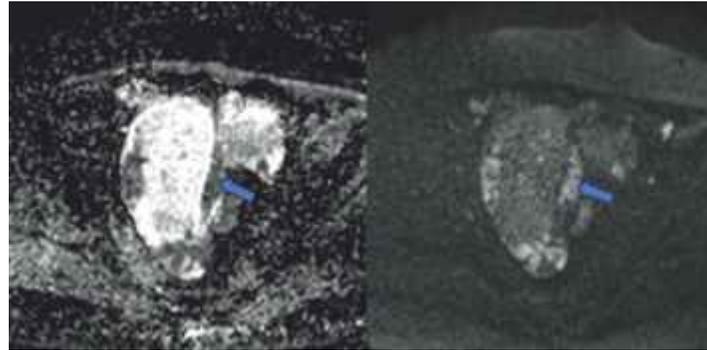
These axial DWI images of pelvis reveal the solid component, along with the thickened fallopian tube showed diffusion restriction (blue arrows)
